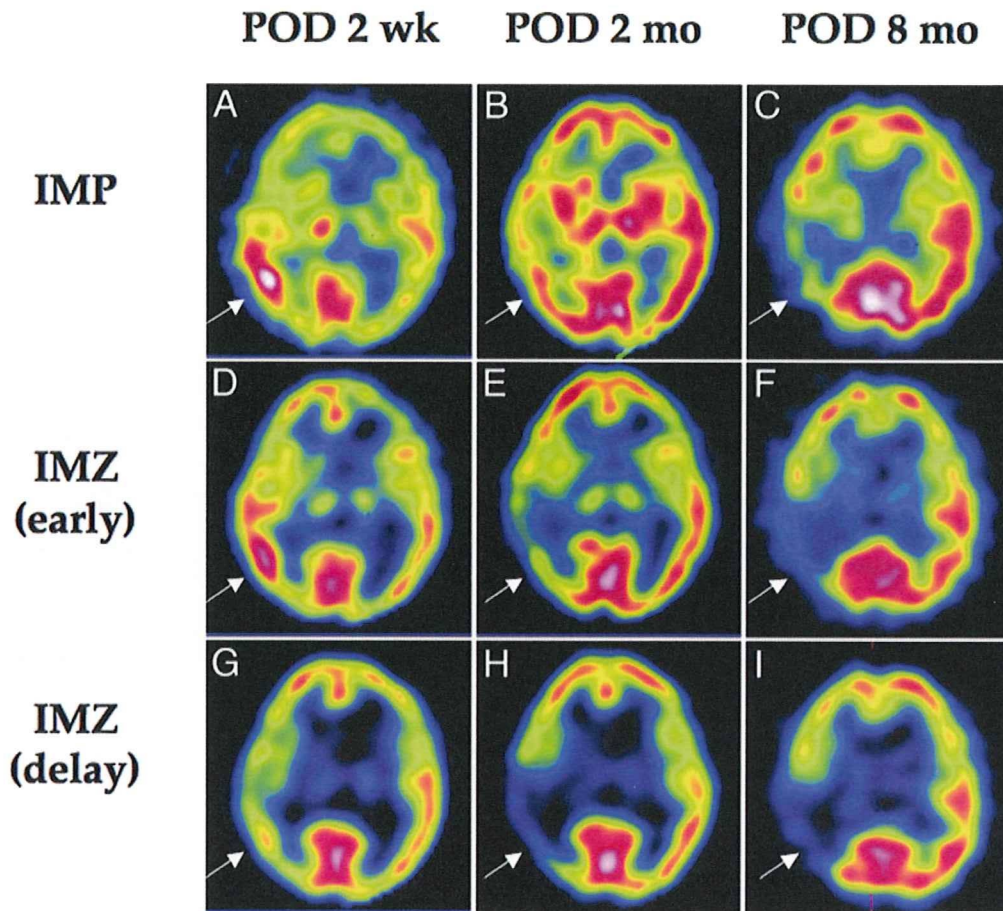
Chronological changes in ¹²³I-IMP and early and delayed ¹²³I-IMZ SPECT images. Iodine-123-labeled iodoamphetamine (A–C) and early ¹²³I-IMZ (D–F) images similarly showing a transient increase in the subacute stage (POD 2 weeks [POD 2 wk; A and D]), followed by progressive decrease in the early and late chronic stages (POD 2 months [POD 2 mo; B and E] and 8 months [POD 8 mo; C and F]) of uptake in the affected regions. Delayed images of ¹²³I-IMZ (G–I) demonstrating delayed decrease of binding of the affected regions between subacute (G) and early chronic (H) stages, which levels off in the late chronic stage (I). Arrows indicate the affected region in the temporal lobe.
